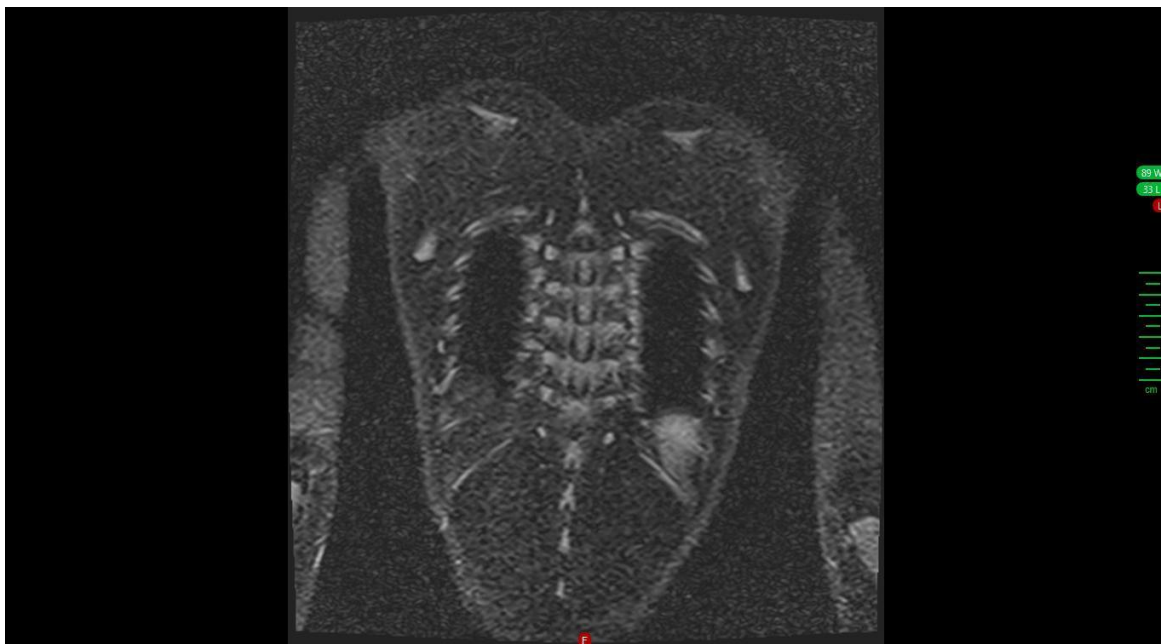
MRI finding: Normal muscle and bone intensity during remission
